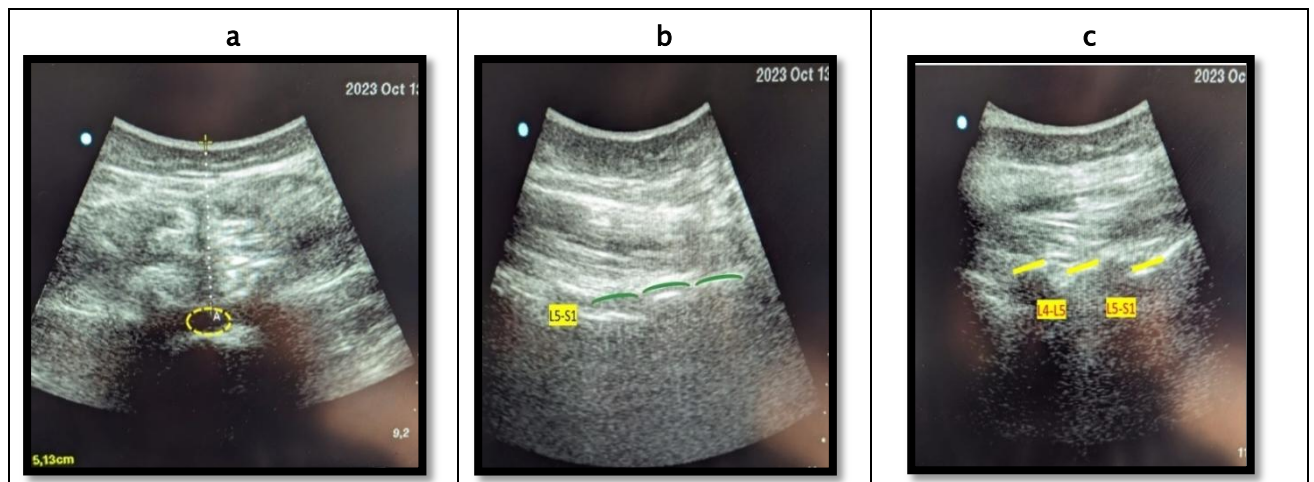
Ultrasound images of anatomical landmark
